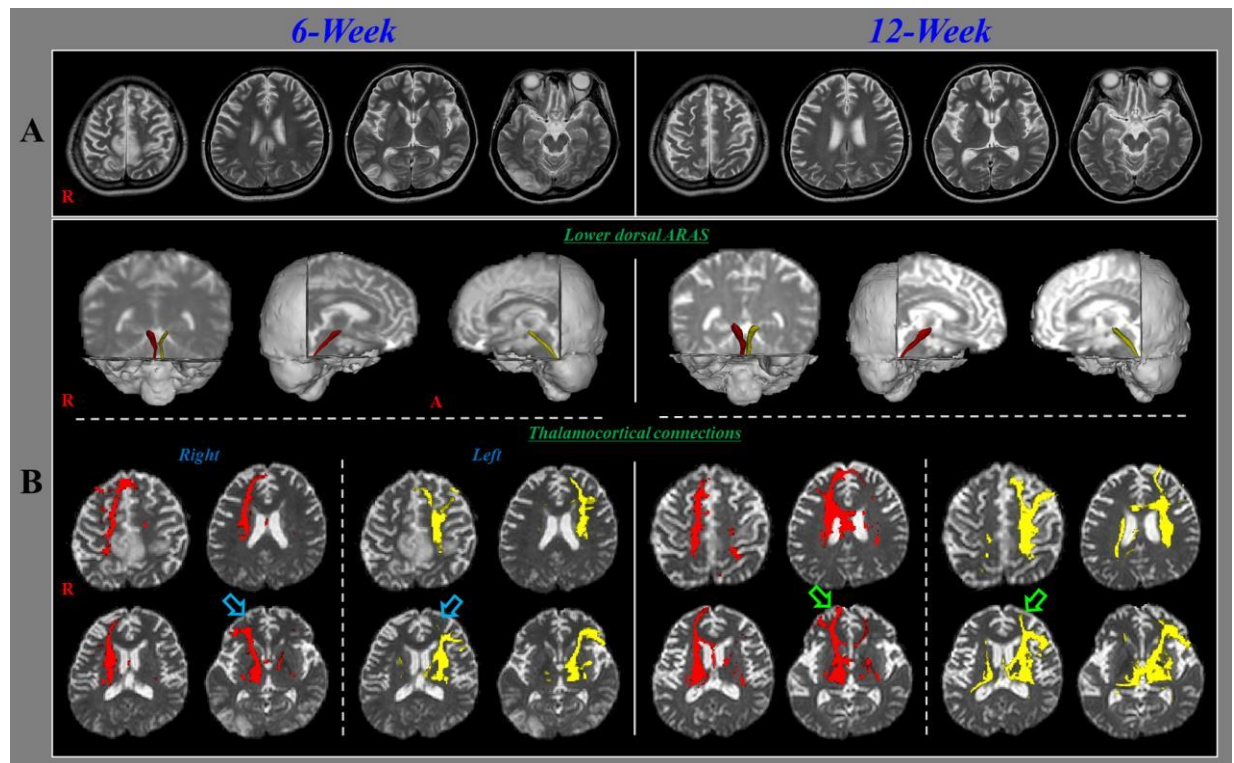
Brain magnetic resonance images obtained at 6 and 12 weeks after HI-BI onset show leukomalactic lesions in the fronto-parieto-temporo-occipital lobes in both hemispheres (B) Results of diffusion tensor tractography (DTT). The lower dorsal ascending reticular activating system does not show a significant change between 6- and 12-week DTT images. By contrast, neural connectivities to both medial prefrontal cortices (blue arrows) are lower on 6-week DTT compared to those on 12-week DTT (green arrows) and show increments to the left lateral PFC.
